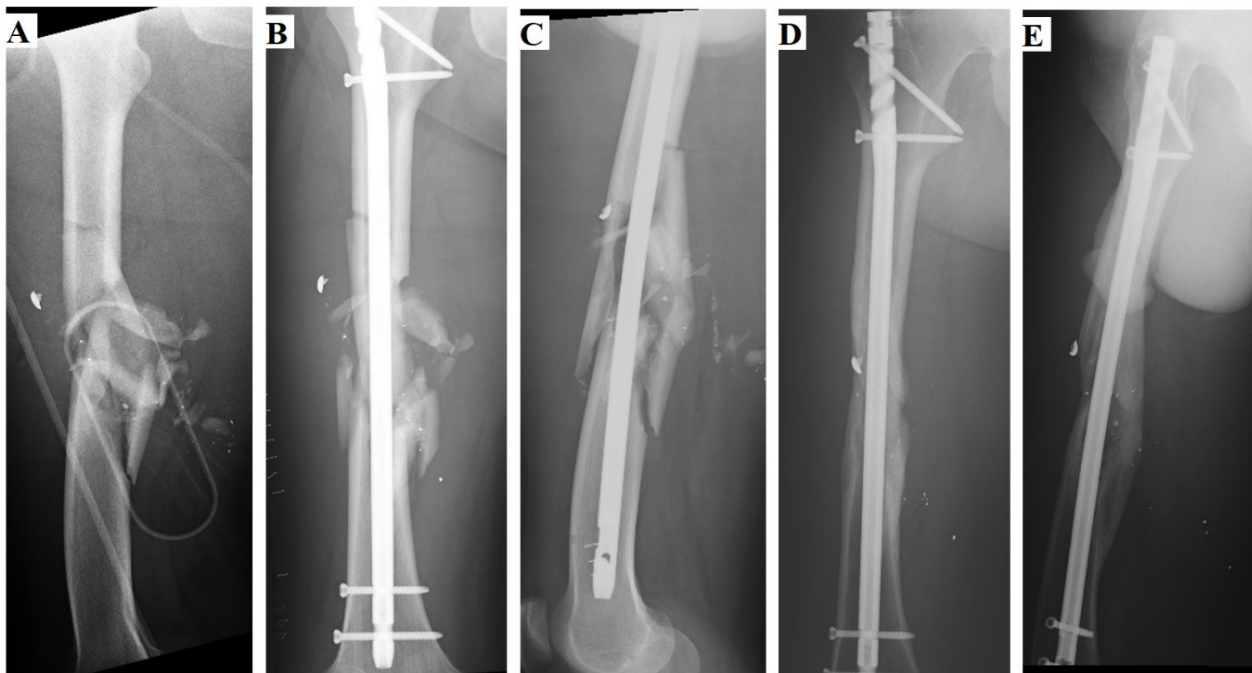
Internal fixation with intramedullary nail fixation in femoral diaphysis fracture (A: The first radiography image, B: Anterior-posterior radiography image after surgery, C: lateral radiography image after surgery, D: Anterior-posterior radiography image after union, E: Lateral radiography image after union)
